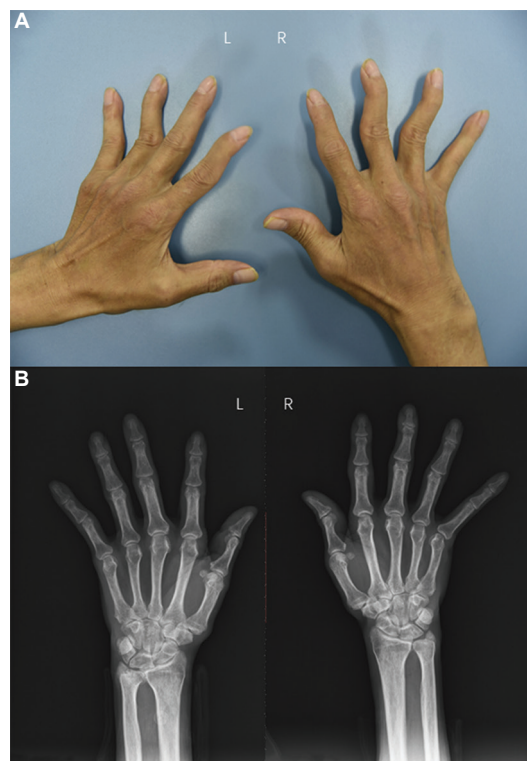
(A) Clinical picture showing swan-neck deformity on both the hands. (B) Radiograph of the hands showing no bone erosions. L, left; R, right.
